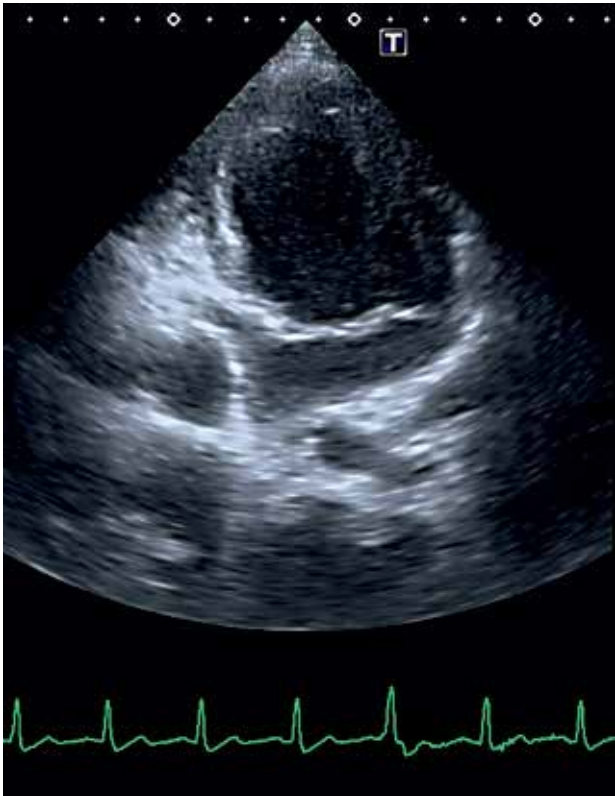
An 18-year-old boy with a univentricular heart is imaged by transthoracic echocardiography.
